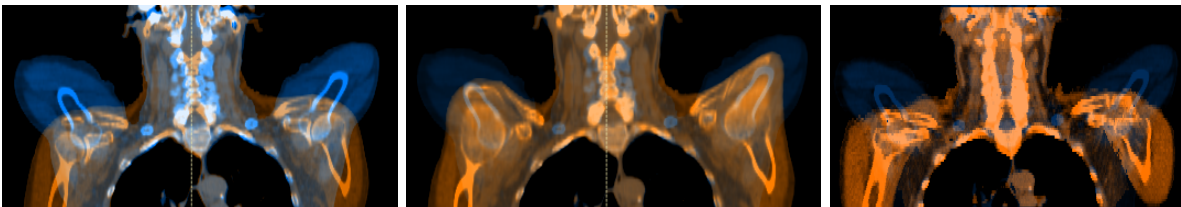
Comparison of the deformation results for the ANACONDA-algorithm and the final version of the developed soft-tissue model for patient 2. A fusion view of the post-treatment CT in orange and in blue the (a) planning CT, (b) ANACONDA-deformation result and (c) soft-tissue model deformation result are shown.
